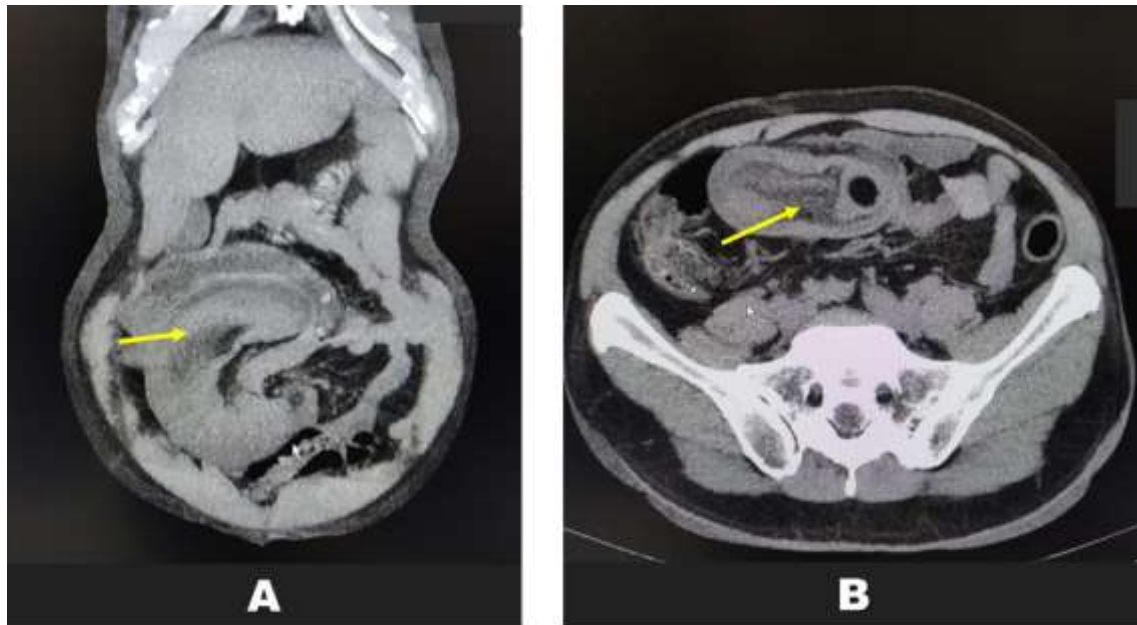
CT scan. A: a typical “sausage-like” image. B: a typical “target” image.
